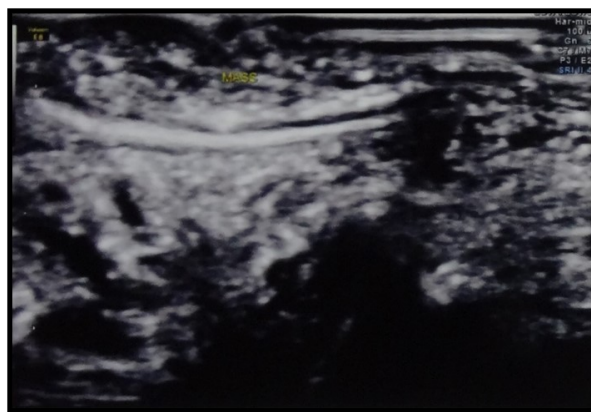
Ultrasound image of the tongue showing the presence of soft tissue mass.
